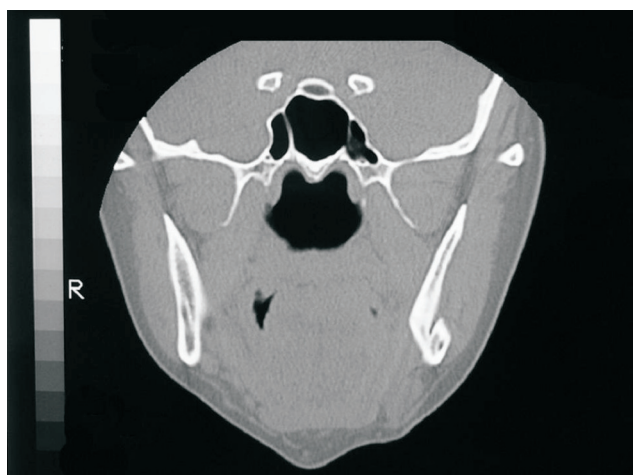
Postoperative computed tomography (36 months)
